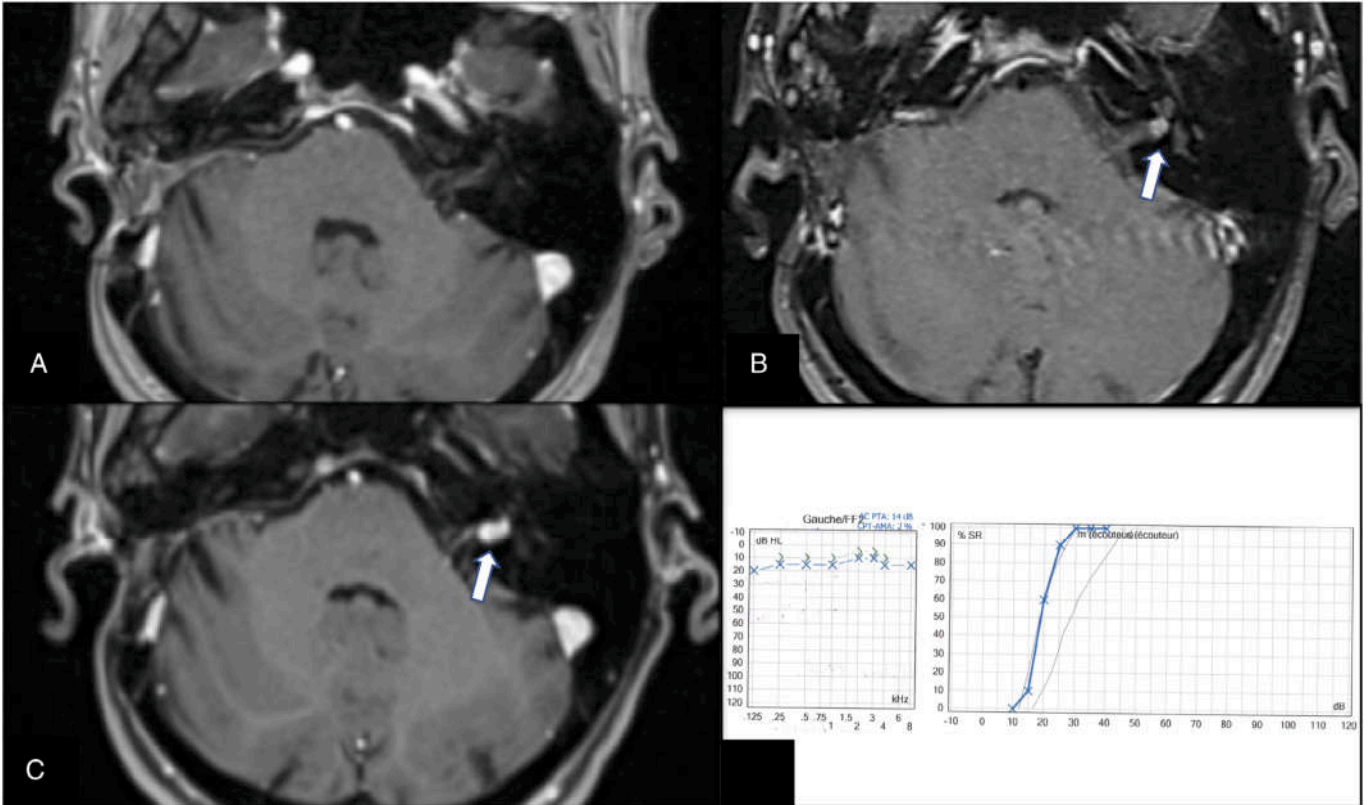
Case 2. (A) Axial T1-weighted gadolinium-enhanced magnetic resonance imaging (MRI) 5 years after vestibular schwannoma (VS) removal on the right side showing no enhancement on both sides. (B) Follow-up gadolinium-enhanced MRI T1 image showing a left-side
